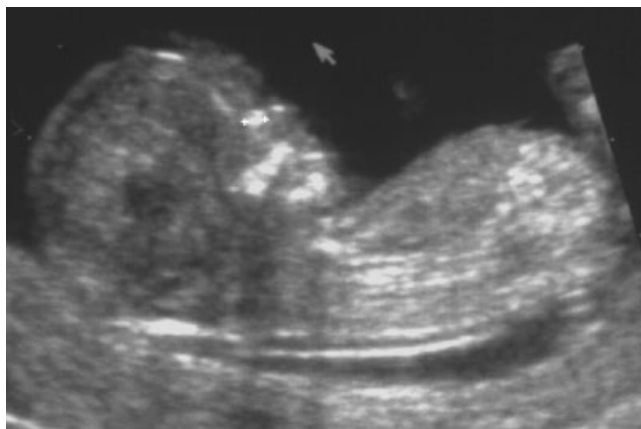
Ultrasound image showing measurement of nasal bone length with calipers in the out-to-out position.
